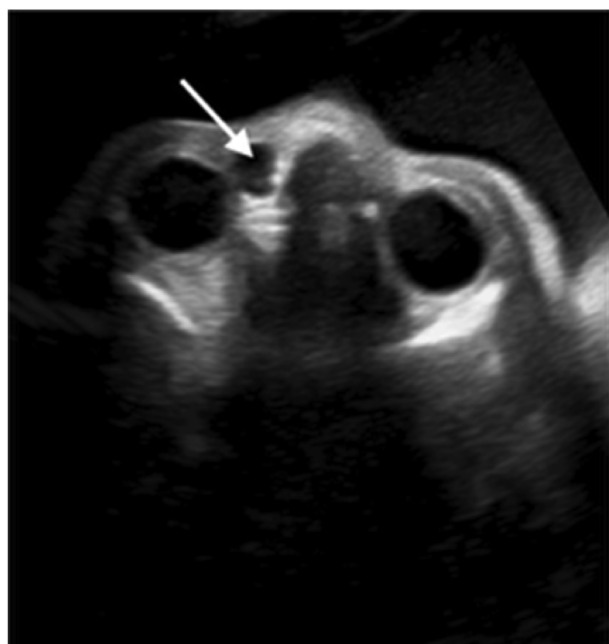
Ultrasound image of prenatally diagnosed unilateral dacryocystocele (arrow).
